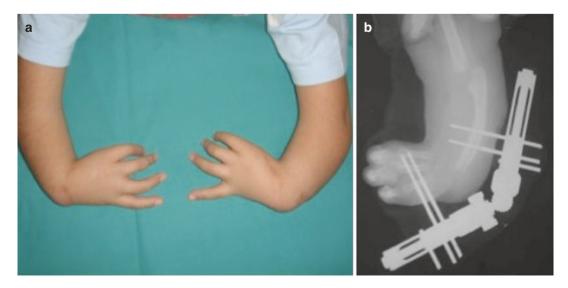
Radial longitudinal deficiency; (a) clinical picture, (b) post-operative x-ray
